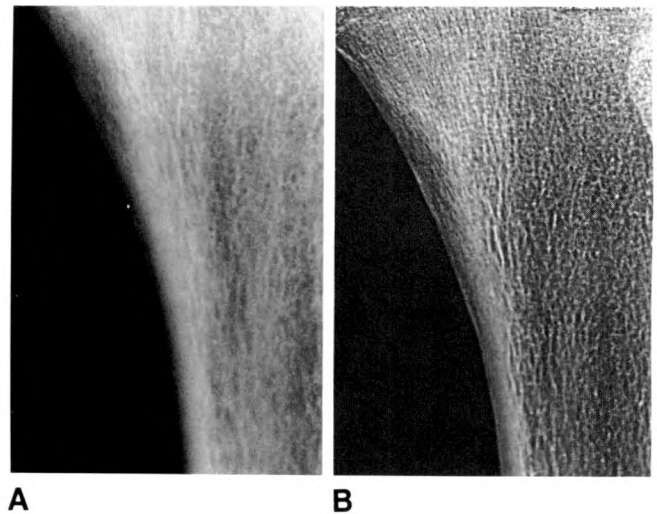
Comparison of conventional film-screen (A) and computed radiographic (B) magnification of osteoid osteoma. Same case as in Fig. 2. Exposure settings and entrance skin exposure were the same in both systems (see legend for Fig. 2).
